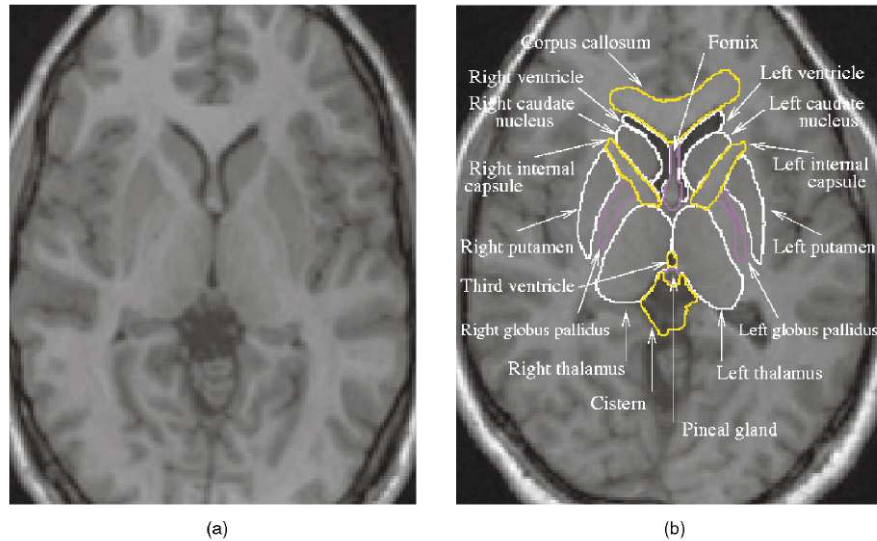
Magnetic resonance image (a) of the human brain. Neuroanatomic structures of the brain are highlights by a neuroanatomist (b). Structures shown in yellow are accurately classified by Procrustes analysis. Image courtesy of Duta et al [113].*
